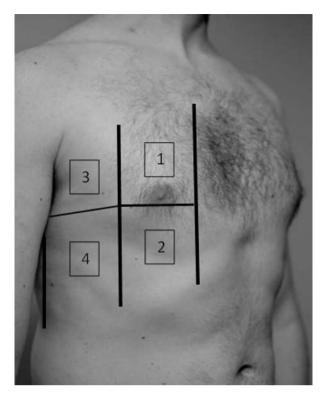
The four chest areas per side considered for complete lung ultrasound examination, modified from Volpicelli et al. Areas 1 and 2 denote the upper anterior and lower anterior chest areas, respectively. Areas 3 and 4 denote the upper lateral and basal lateral chest areas. The horizontal lines are from median line: parasternal line, anterior axillary line and posterior axillary line, respectively [38]
